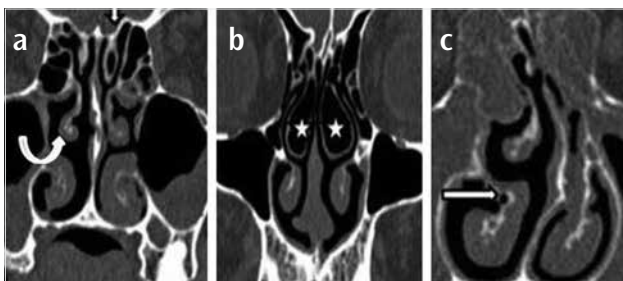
a-c. Coronal CT images of different patients showing: pneumatization of left superior concha (arrow) and paradoxically curved right middle concha (curved arrow) (a), pneumatization of bilateral middle conchae (asterisks) (b), pneumatization of right inferior concha (arrow) (c)
